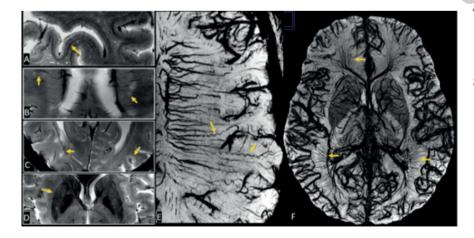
Seeing is believing: 7 T potentials show (A) cortical layers, (B) central vein sign of multiple sclerosis (MS), (C) MS lesion developing along veins, not fiber tracts and cortical lesions, (D) varied age-related iron deposition, (E) small arterial tortuosity with corkscrew appearance, (F) whole brain microvascular mapping on ultrasmall-superparamagnetic-iron-oxide (USPIO)-enhanced magnetic resonance imaging.
